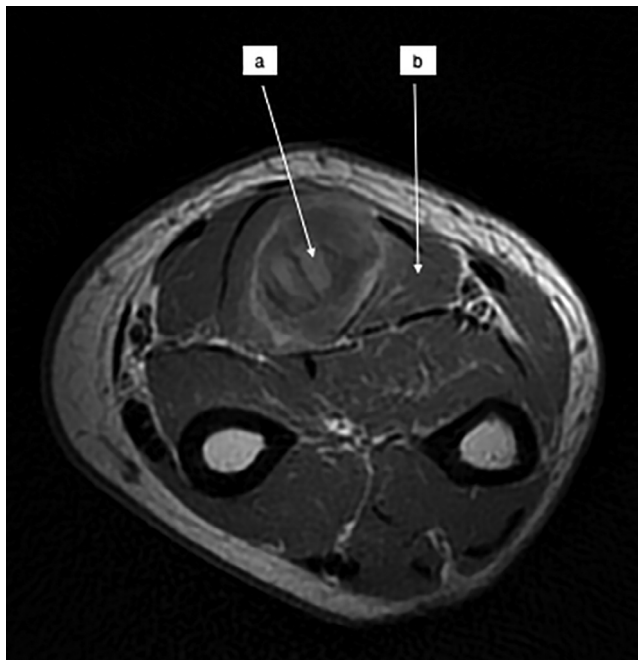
Forearm MRI in the axial plane, showing a focal haematoma (a) in the flexor digitorum superficialis muscle (b).
